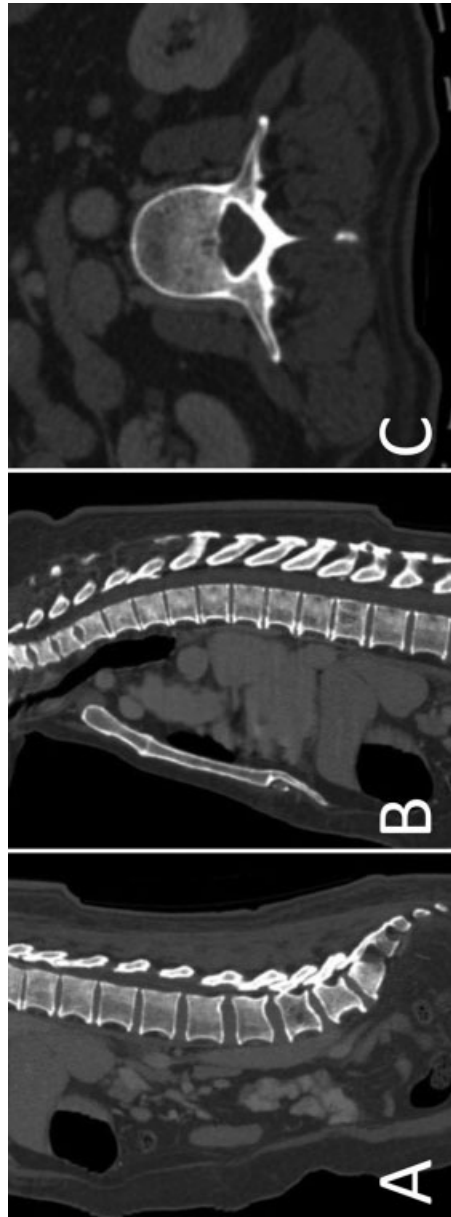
Reformatted mid-sagittal (A, B) and axial (C) CT images showing mild sclerotic density with loss of normal trabecular pattern in the posterior parts of the vertebral bodies corresponding to the abnormal T1-hypointense areas seen in —Fig. 2. CT, computed tomography.
